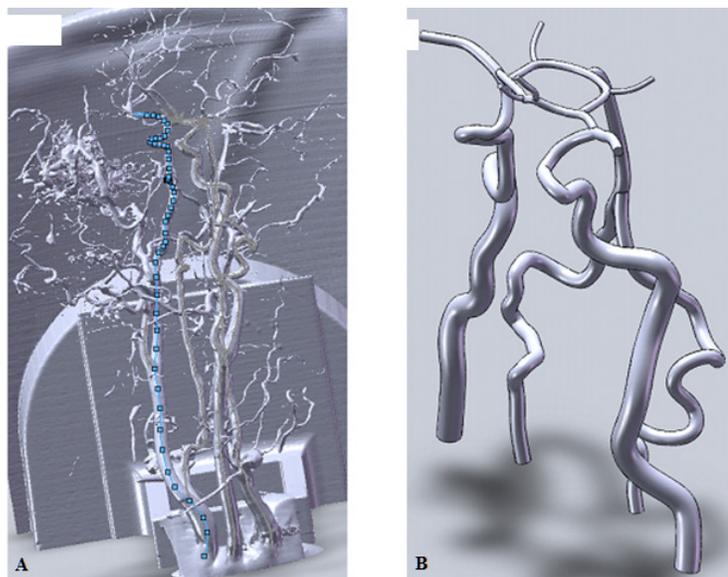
A CT scan of the neurovasculature was imported into Solidworks. The pathline for the right ICA (blue line) is shown. 2-28B. The Circle of Willis and truncated segments of the feeder vessels were created in Solidworks by lofting circular cross sections along pathlines.
